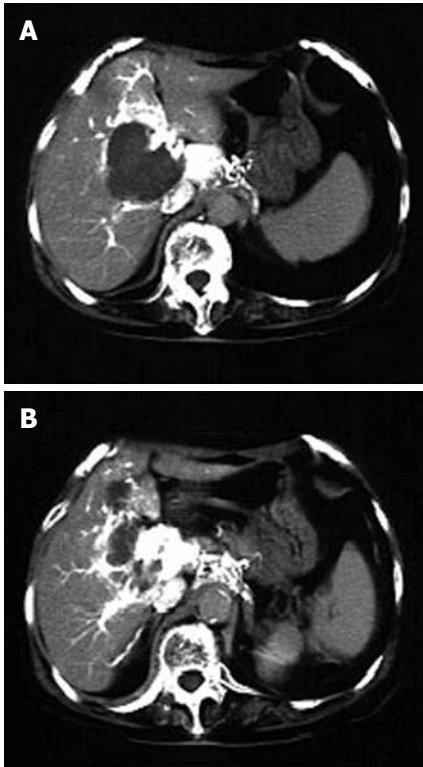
Abdominal computed tomography scan with contrast. A: A hypovascular mass in the porta hepatis; B: Developed collateral vessels around the mass.
